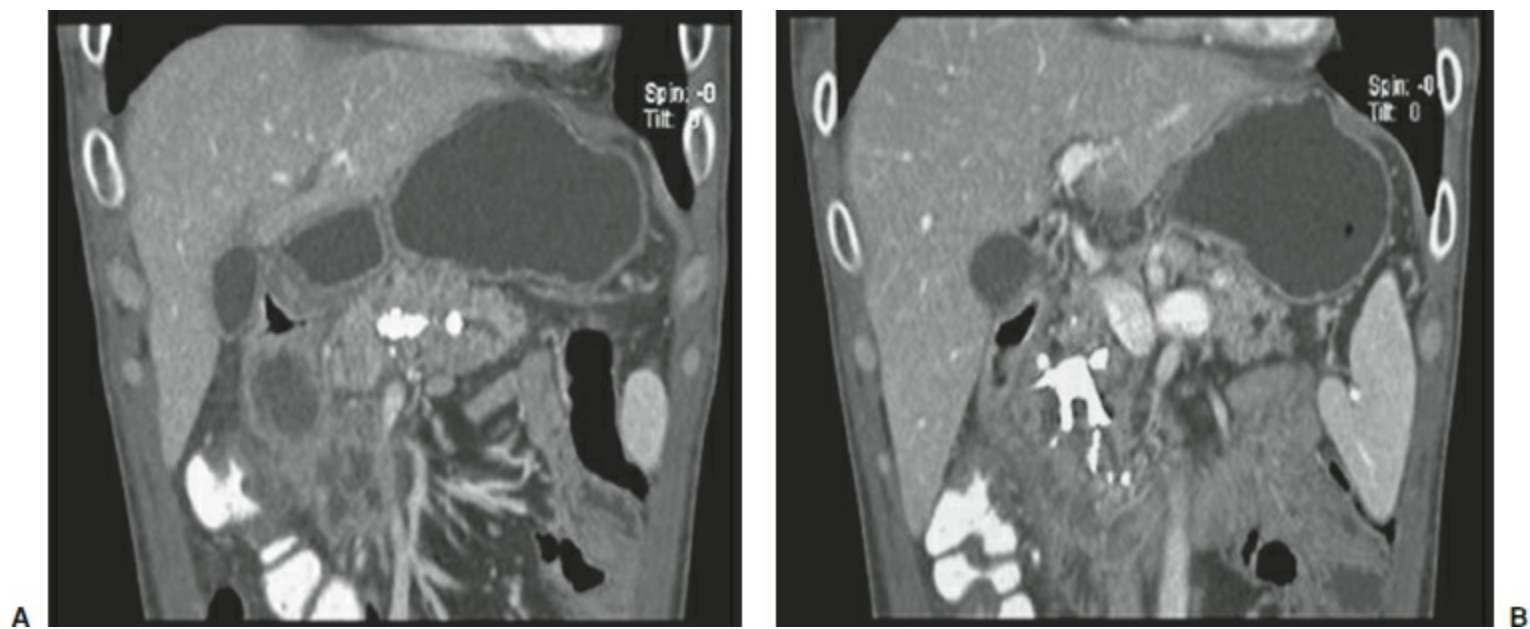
Contrasted CT scan in venous phase, coronal images showing (A), dilated main pancreatic duct with intraductal stones and (B), significant fibrotic disease burden in the head of the pancreas with intraparenchymal and intraductal calcifications.
